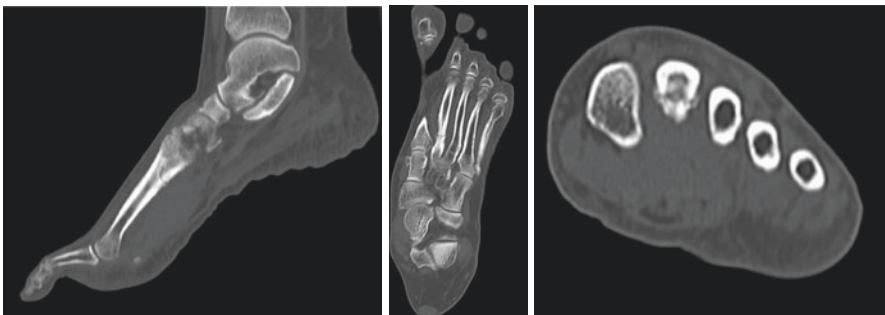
Sagittal, coronal, and axial images of CT scan of foot showing a healing stress fracture of the base of the second metatarsal
